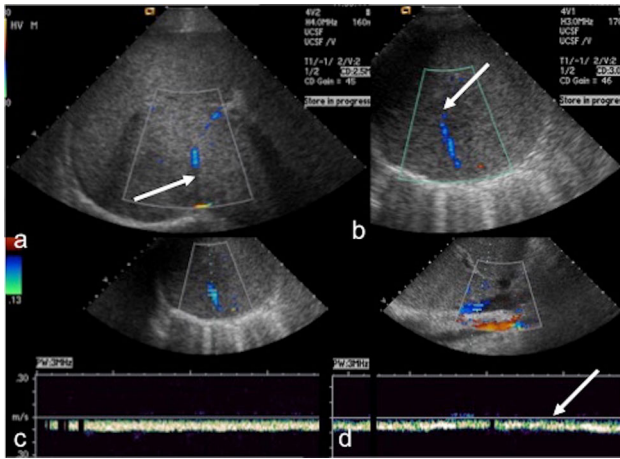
A 33-year-old postpartum woman who presented with new ascites. a, b Doppler US images of the liver demonstrate interrupted flow between the middle and right hepatic veins. c, d Spectral Doppler interrogation of the right hepatic vein and IVC demonstrates abnormally monophasic waveforms and absent respiratory variation
